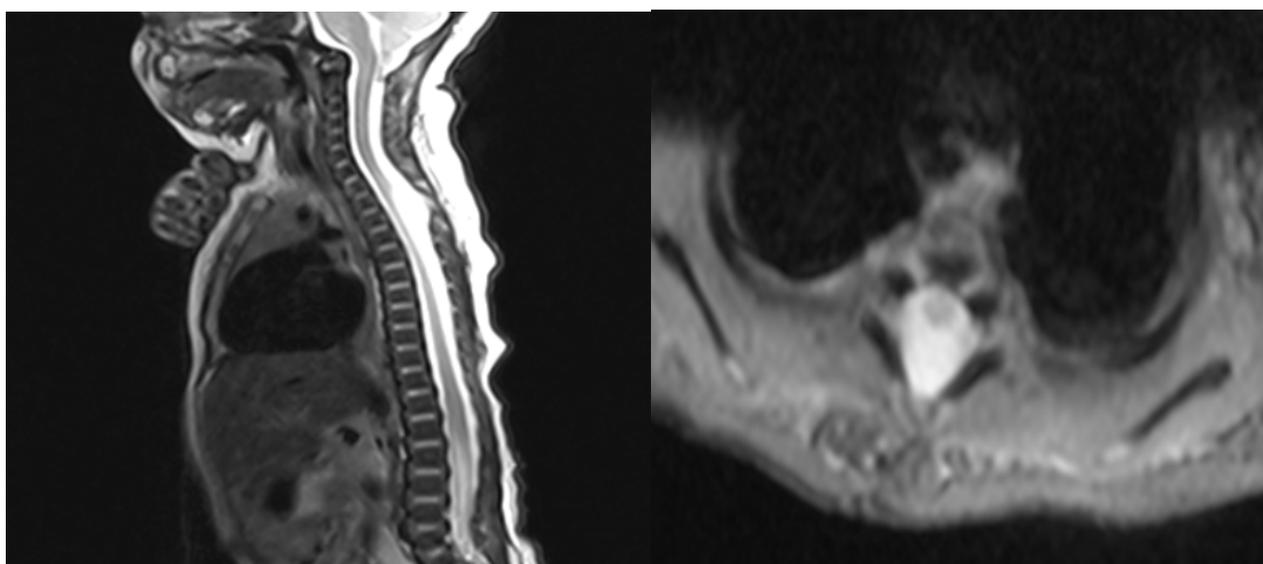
Postoperative Cervical Meningomyelocele, sagittal and axial MRI
